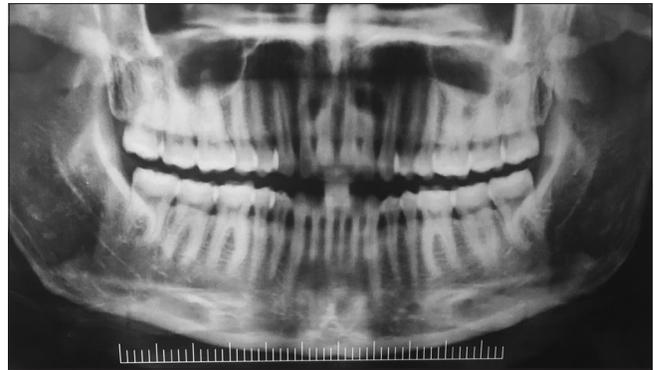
Post-operative orthopantomogram
